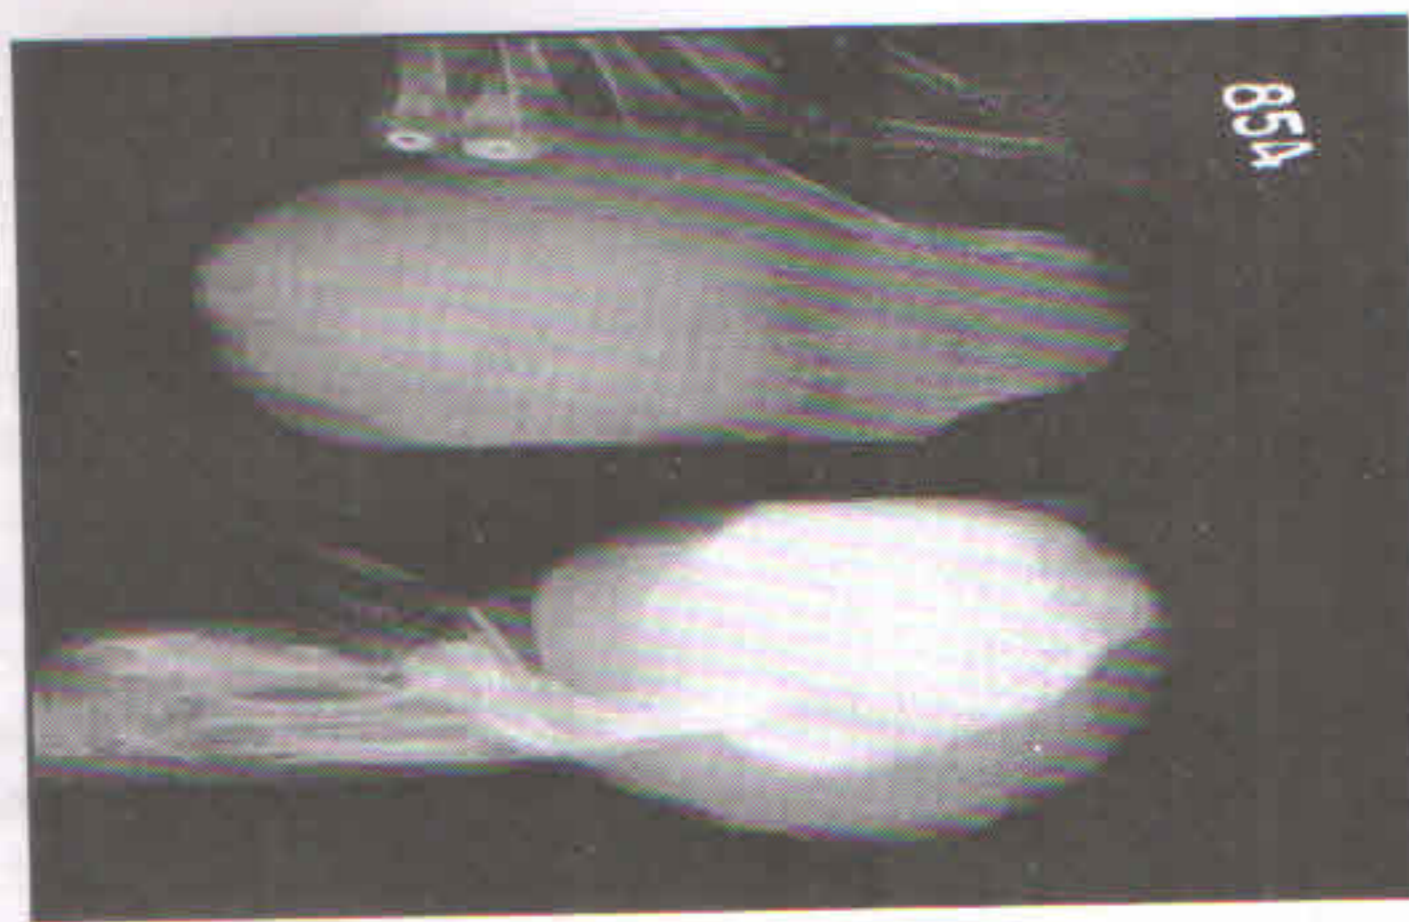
X-Ray showing a Calcified, soft tissue globular swelling without bony involvement
